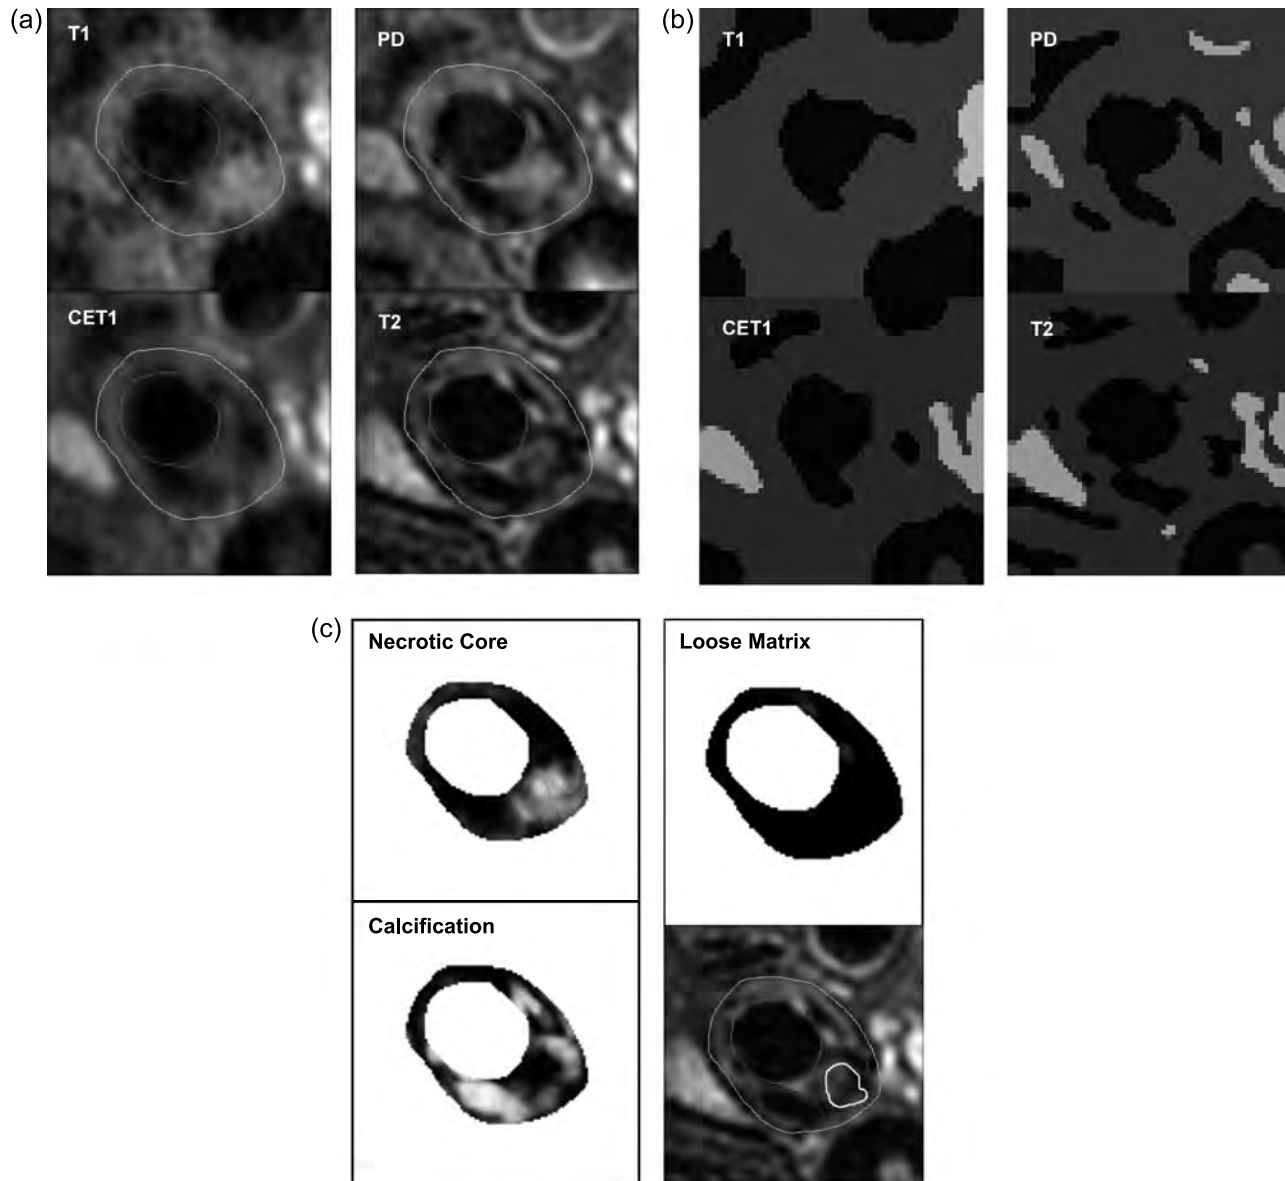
(a) MR images (b) pre-segmentation (c) probability map and final segmentation (1 necrotic core and 3 calcifications are displayed in a T2 image).
